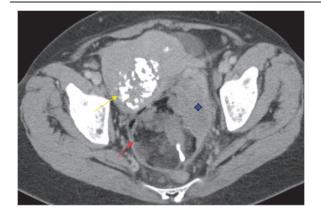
Axial CT left ovarian mass (red arrow) containing fat, calcification and large soft tissue component (blue marker). Mass is causing rightward displacement of the uterus, which contains calcified fibroids (yellow arrow).
